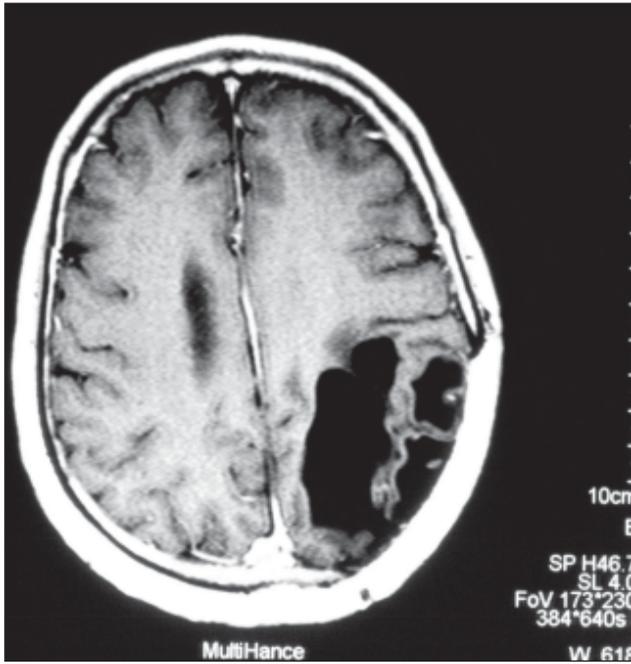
Brain CT from 2008
